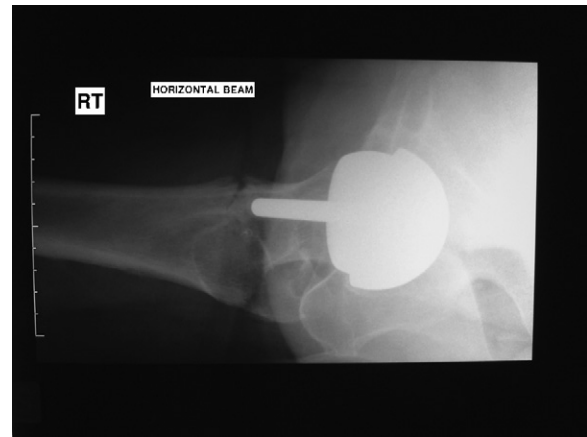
Patient 2 radiograph lateral right hip at presentation.
